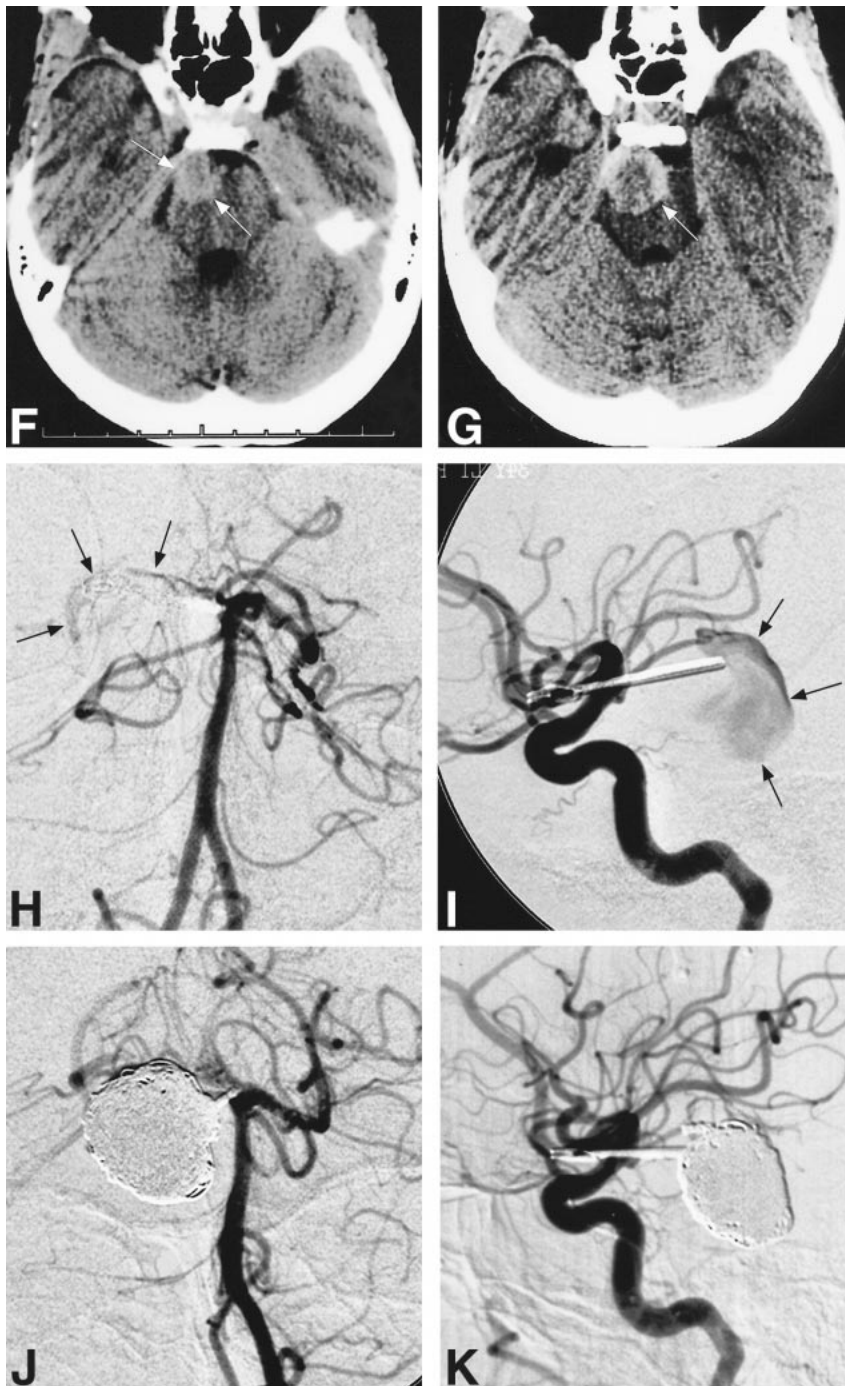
(continued). *F–K*, 17 weeks after surgical clipping, the patient presented with recurrent headaches and a right third nerve palsy. Brain CT scans (*F* and *G*) show interval aneurysm growth from 16 mm to 21 mm (*arrows*) despite prior surgical clipping of the proximal right P1 PCA segment. Cerebral arteriograms (*H* and *I*) show renewed opacification of the aneurysm (*arrows*) via posterior communicating artery to a greater degree than the PCA. Cerebral arteriograms after GDC coiling procedure (*J* and *K*) now show complete occlusion of the aneurysm and improved visualization of the distal right PCA.
